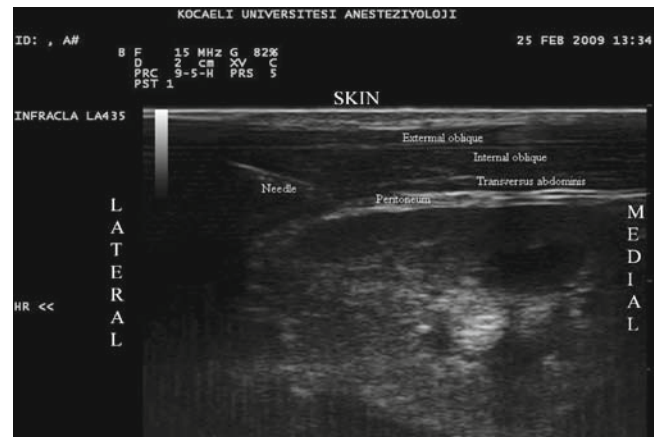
Ultrasonographic view of the transversus abdominis plane block in a 2-month-old infant (left side)
